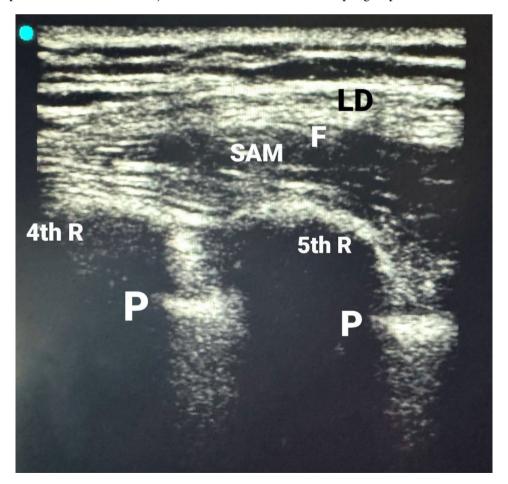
Ultrasound view of SAP block, F: Fascia, LD: Latissimus dorsi muscle, P: Pleura, R: 4th and 5th rib, and SAM: Serratus anterior muscle
